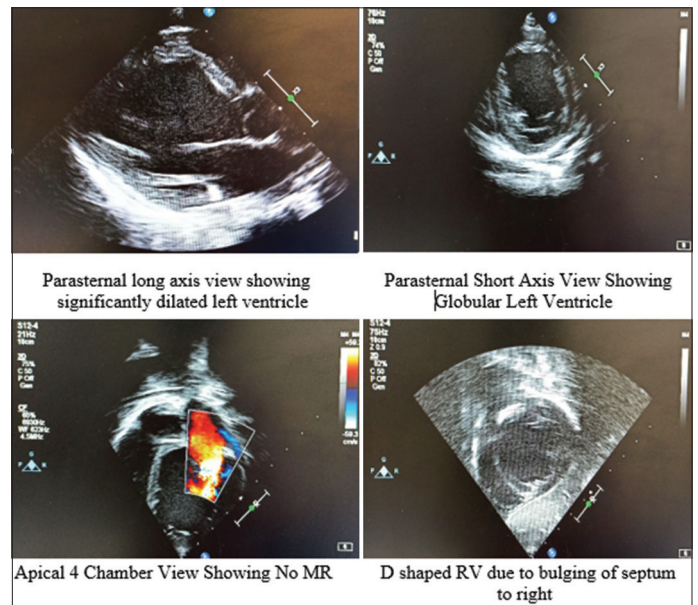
Echocardiography revealing dilated cardiomyopathy with a globular left ventricle, with no mitral regurgitation and D shaped right ventricle
